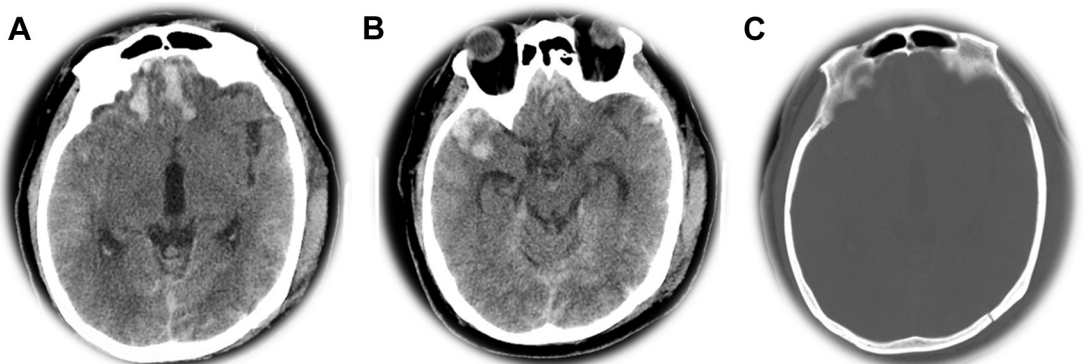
Contracoup contusions in an 80-year-old patient who fell backwards from standing. Axial CT images show frontal (A) and temporal (B) hemorrhagic contusions associated with posterior parietal fracture (C).
